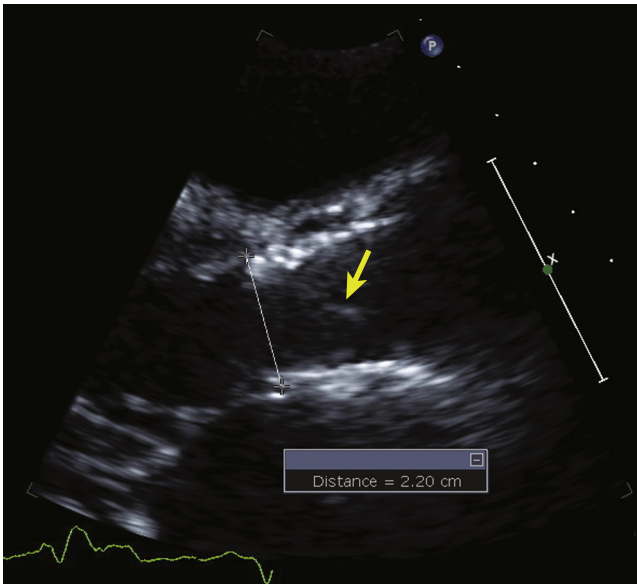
TAVR on parasternal long-axis window. The LVOT diameter should be measured as the outer to outer edge diameter at the lower end of the valve stent frame. *Arrow* indicates the aortic valve leaflets within the TAVR frame.
